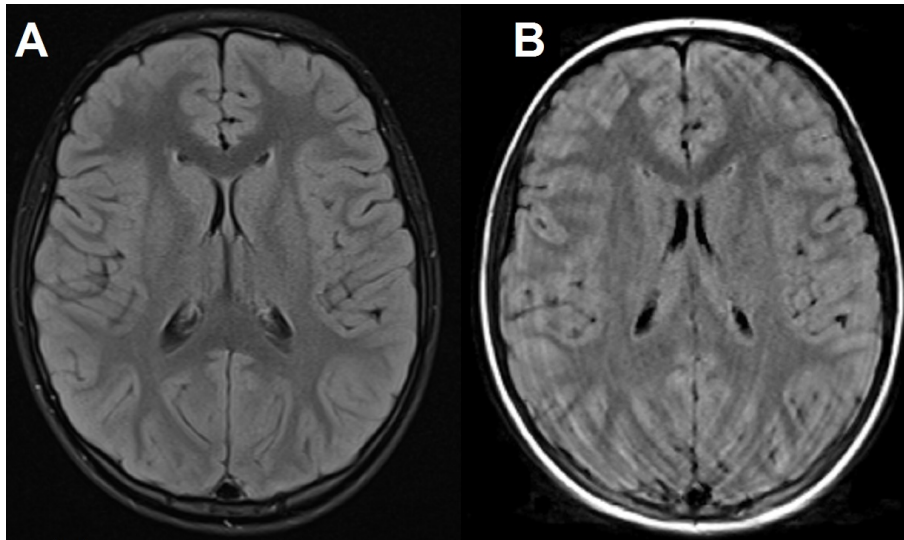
Conventional (A) and corresponding synthetic (B)  $T_2$ -FLAIR-weighted image showing the predisposition of the QRAPMASTER-approach for motion artefacts.
